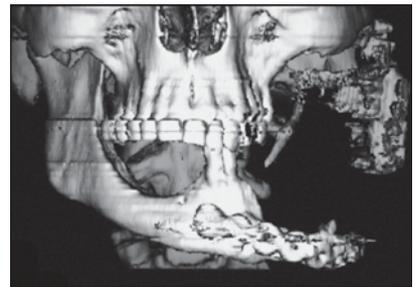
CT image showing the resorption of the graft, the displacement of the TMJ prosthesis, and the bone defect of the left hemimandible.
